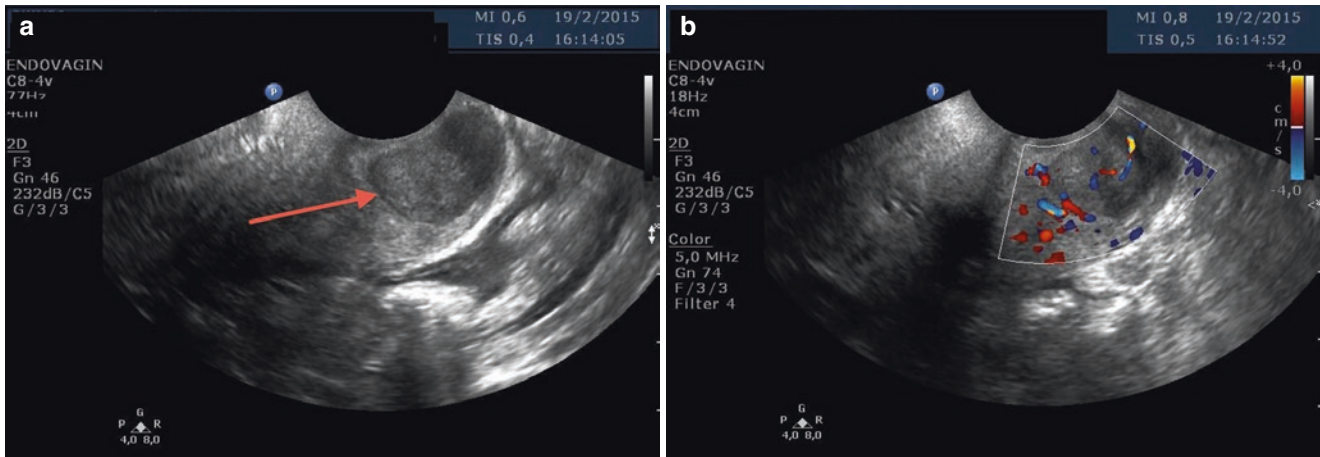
(a) Longitudinal section, showing hypoechoic and intramural myoma in the posterior region of the cervix (*red arrow*), compressing the cervical canal. (b) Color Doppler showing central and peripheral vasculature in the myoma
